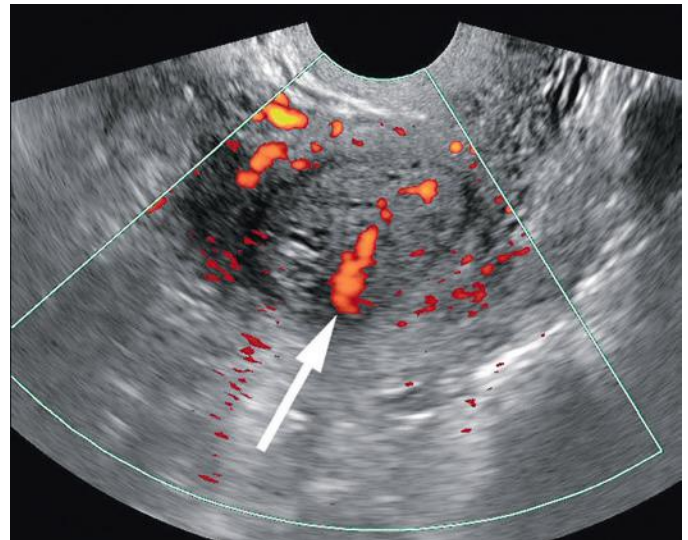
A 68-year-old woman with postmenopausal bleeding. Transverse power Doppler image of the uterus shows cystic endometrial thickening with a single vascular pedicle (*arrow*) consistent with a focal abnormality, specifically an endometrial polyp. As is often the case with focal endometrial abnormalities, blind endometrial biopsy was negative, but a benign polyp was diagnosed on hysteroscopic polypectomy.
